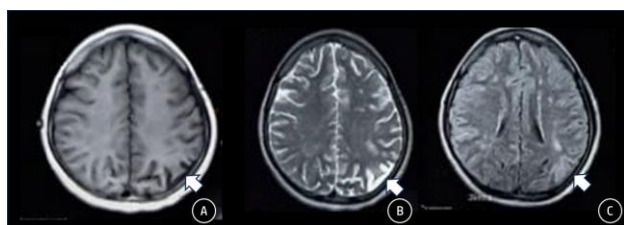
Head MRI image hypointense in T1 (a), hyperintense on T2 (b) and FLAIR (c) showing ischemic lesion in left parietal lobe (arrow).
